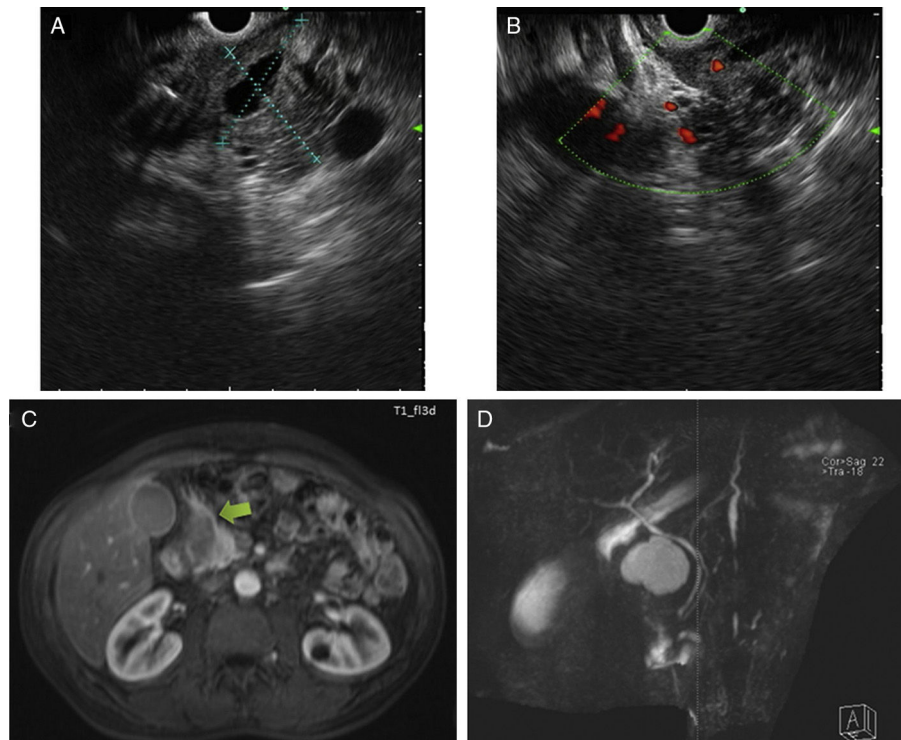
A and B) Endoscopic ultrasound defined a largely hypoechoic lesion, with some anechoic areas and poorly defined limits. Color Doppler ultrasound was negative for vascular flow. C and D) The magnetic resonance imaging scan shows a spontaneous hyperintense lesion on T1 and T2 in the proximity of the gastroduodenal artery, with no enhancement after gadolinium administration. No communication with the common bile duct or pancreatic duct was observed.
